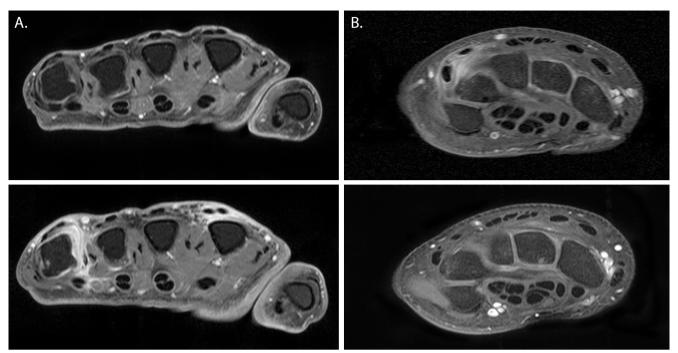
Examples of MRI at presentation with clinically suspect arthralgia (CSA) (top panel) and at IA development (bottom panel), showing joints (A) from no inflammation to clinical synovitis and (B) resolution of subclinical inflammation. Presented in (A) are: (top panel) left MCP joints with no subclinical inflammation as detected by MRI, and (bottom panel) left MCP joints of the same patient with synovitis in MCP5 and tenosynovitis in MCP2 and 5. According to clinical examination the patient developed clinical synovitis in the left MCP2 (depicted), left MCP5 (depicted), left proximal interphalangeal (PIP)2 and right PIP5 joints (both not imaged). From a different patient (B) are presented: (top panel) right wrist joint with tenosynovitis in the extensor carpi ulnaris tendon, and (bottom panel) right wrist joint of the same patient without MRI-detected subclinical inflammation despite progression to inflammatory arthritis at the patient level. The patient developed clinically apparent synovitis in the left PIP3 joint (not imaged). All images were made in T1-weighted fast spin echo (FSE) sequence with frequency selective fat saturation in the axial plane after gadolinium contrast injection.
